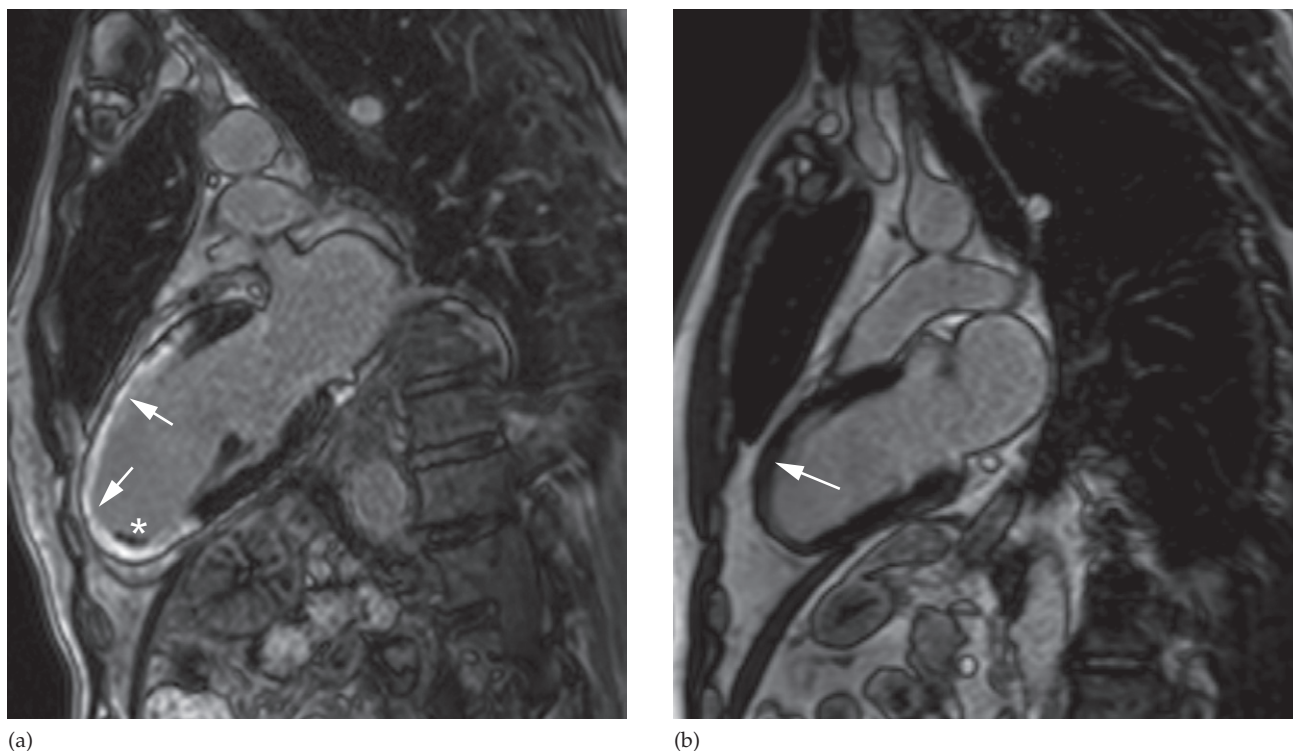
Myocardial infarction on MRI. T1-weighted inversion recovery image acquired at 15 minutes after injection of gadolinium (late gadolinium enhancement). (a) There is a large area of hyperintensity (due to slow clearance of gadolinium) in the anterior wall and apex (arrows) consistent with scar tissue, suggesting transmural myocardial infarction. Also note an apical thrombus (*). (b) In a different patient, the normal myocardium demonstrates uniform low signal intensity (arrow).
